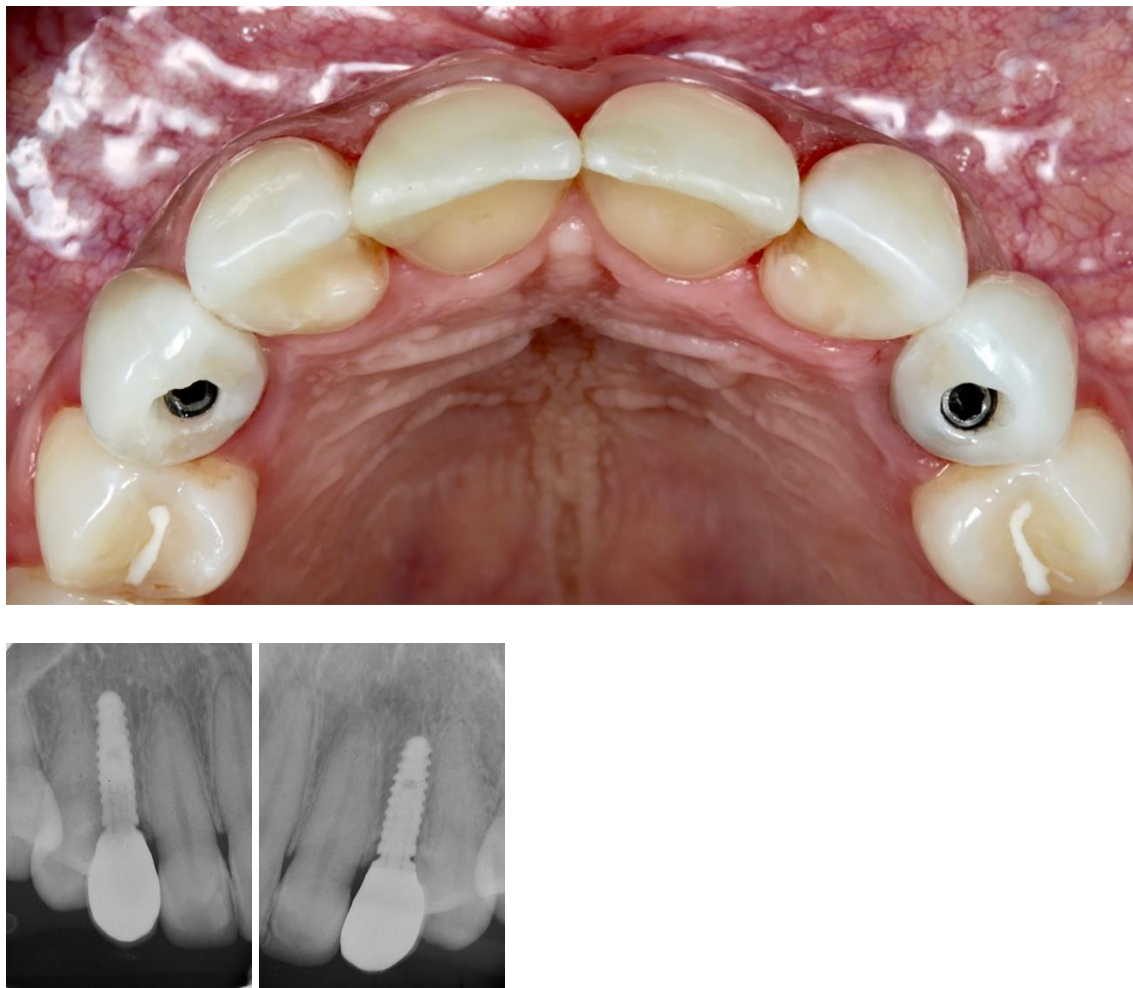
Monolithic high-translucency zirconia crowns in place. Periapical radiographs of final restorations.
